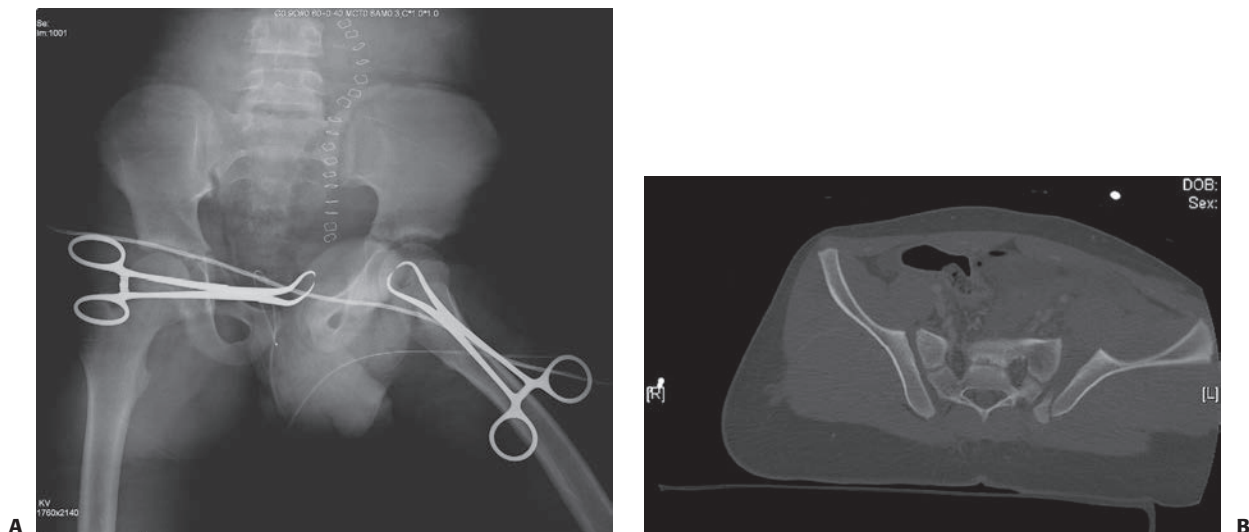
This radiographic series highlights treatment of an unstable pelvic fracture with hemodynamic instability. A: Anteroposterior pelvic radiograph of a 12-year-old boy who was a pedestrian hit by a car. There is a wide symphysis and a displaced fracture adjacent to the left sacroiliac joint. The towel clips seen on radiograph are to hold a sheet (sling) around the pelvis to help temporarily control hemorrhage. B: CT scan showing the displaced posterior injury.
